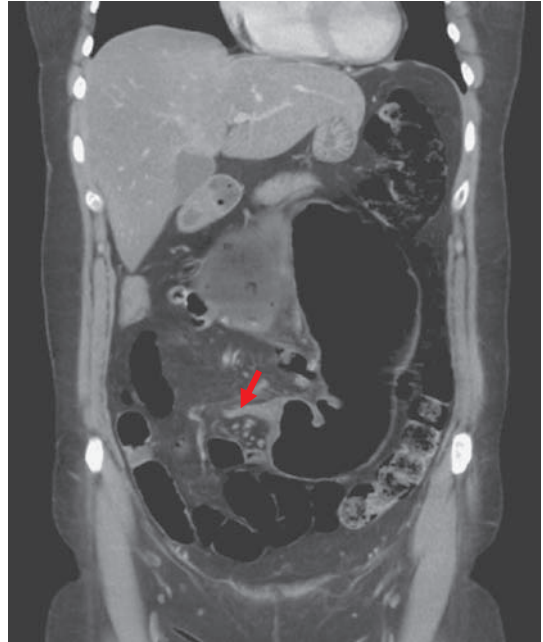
Cecal volvulus on transverse CT scan section with the beaking effect (*arrow*).
